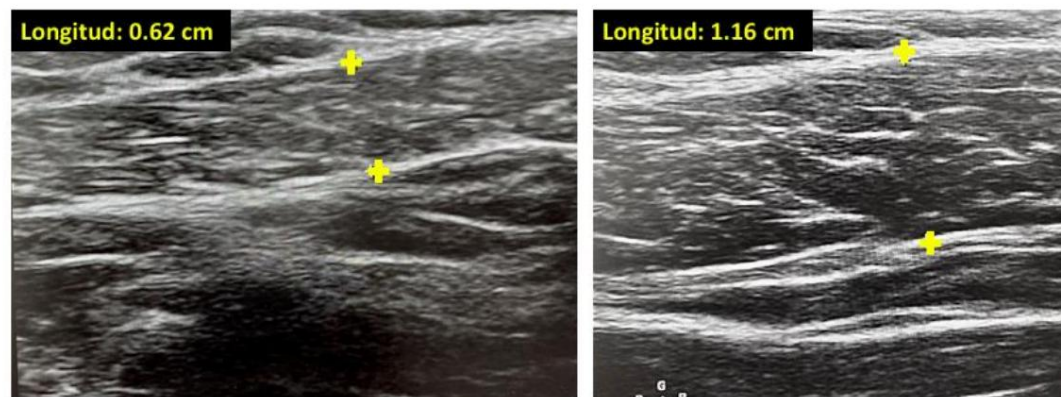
Ultrasound cross section of the upper right trapezius 0.62 cm, and left 1.16 cm.
